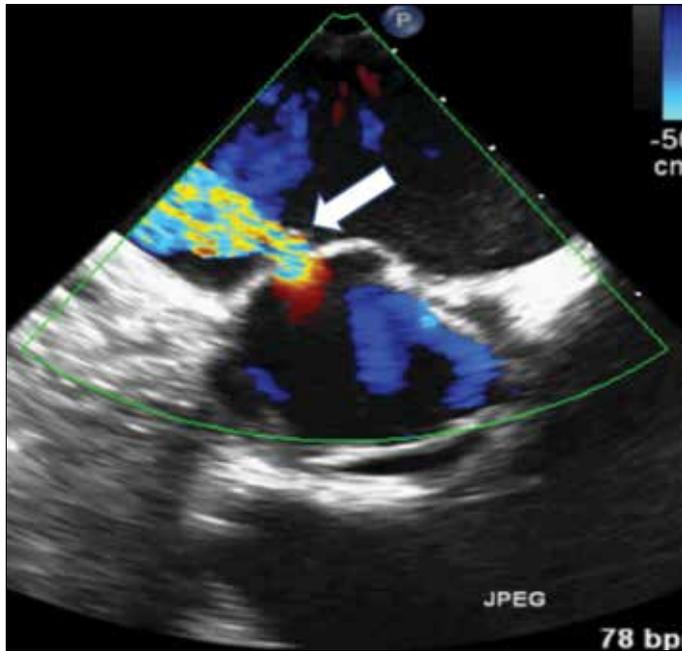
Transesophageal echocardiogram demonstrating an eccentric regurgitant jet (white arrow) through the perforated anterior mitral valve leaflet
